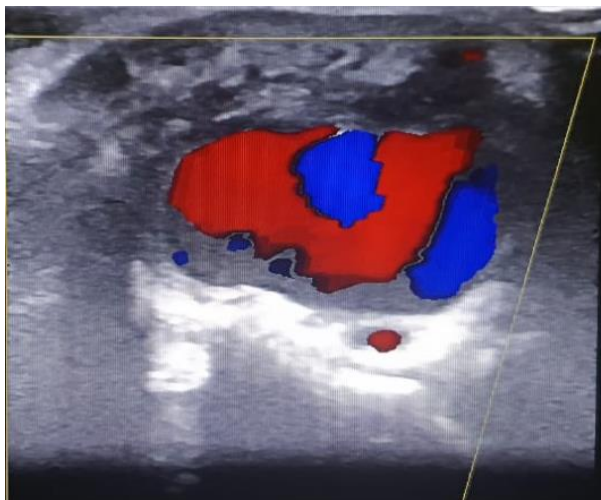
Color Doppler turbulence with a Ying-Yang appearance
